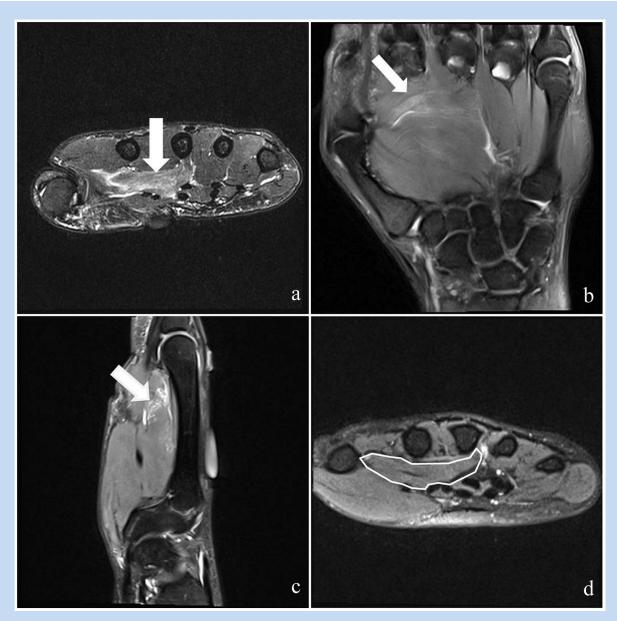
T2 magnetic resonance images demonstrate feathery edema (arrow) within the adductor pollicis longus in (a) axial, (b) coronal, and (c) sagittal planes. (d) Normal axial T2 image of the hand with the adductor pollicis longus outlined, shown for comparison.
